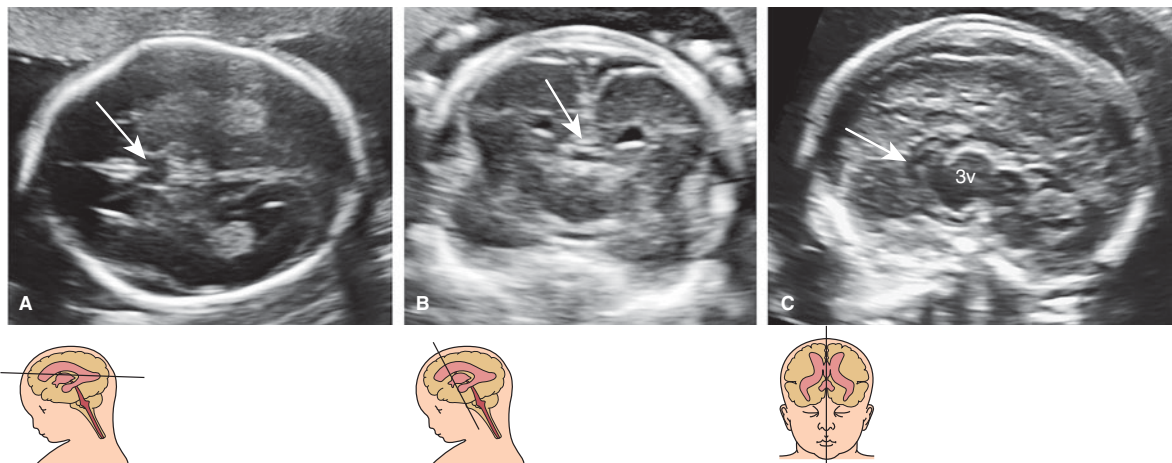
Partial agenesis of the corpus callosum. (A) In the axial plane, the cavum septi pellucidi (arrow) is present. (B) In the coronal plane, the corpus callosum (arrow) is seen bridging between the two hemispheres, although it appears thinner than usual. (C) Only in the sagittal plane is the anomaly clearly demonstrated. The cavum septi pellucidi/corpus callosum complex (arrow) is present but is much smaller than normal; it does form a complete arch over the third ventricle (3v), but only reaches about midway. (Reproduced, with permission, from Tutschek B, Pilu G: Virtual reality ultrasound imaging of the normal and abnormal fetal central nervous system. *Ultrasound Obstet Gynecol.* 2009;34(3):259–267.)
